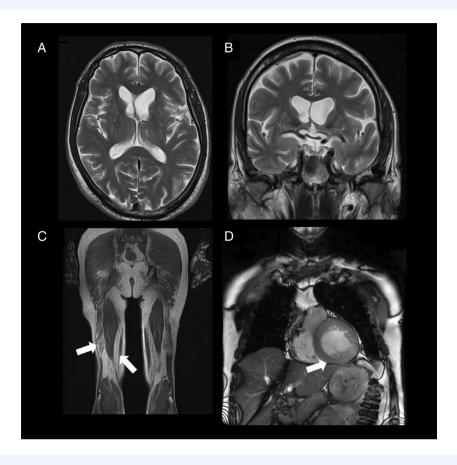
(A, B) Brain MRI on t2-weighted sequences showing moderate atrophy of both caudate nuclei with constitutional asymmetry between both ventricular horns. (C) Muscle MRI on t1-tse sequences showing severe fatty infiltration of semimembranosus and biceps femoris muscles (arrows) in both legs. (D) Cardiac MRI on FIESTA sequences showing moderate hypertrophy (12 mm) of the left ventricle lateral wall (arrow).
